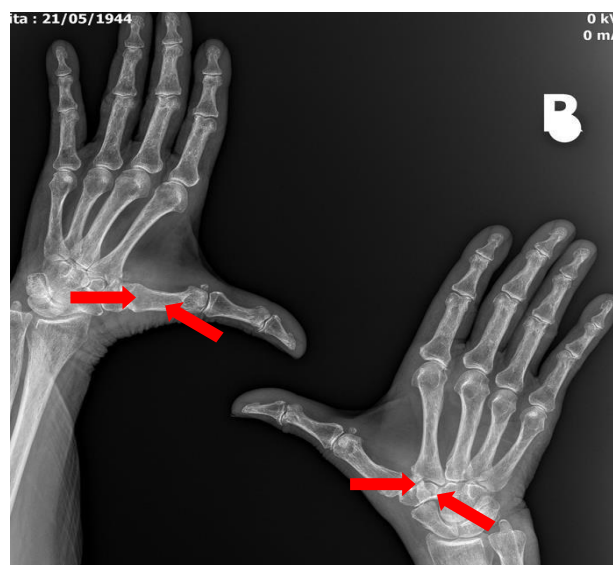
Kapandji radiographic projections of both hands documenting grade 2 bilateral rhizarthrosis with slight reduction of joint space (arrows).
